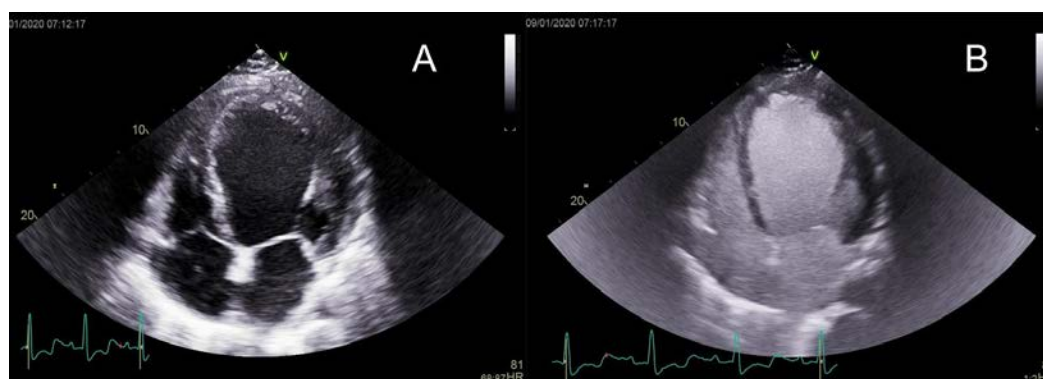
Dilated cardiomyopathy is shown using contrast echocardiography.
